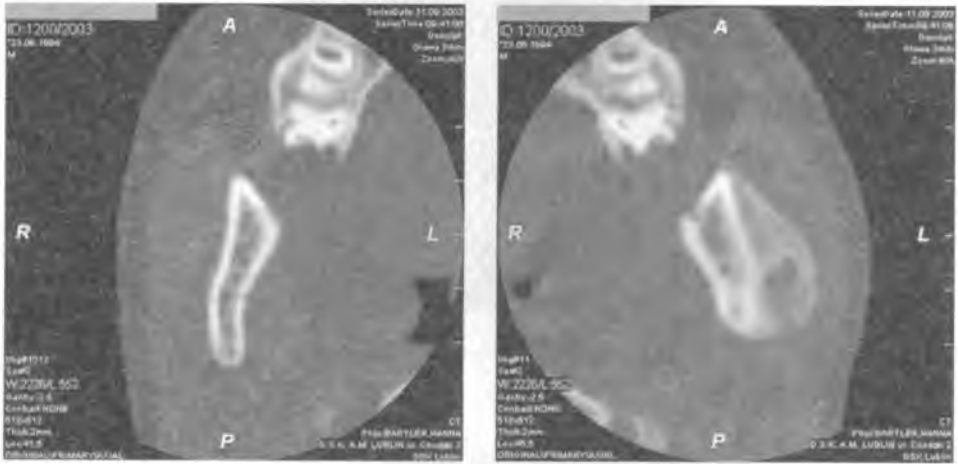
CT scan: on the left side – fibrous dysplasia
